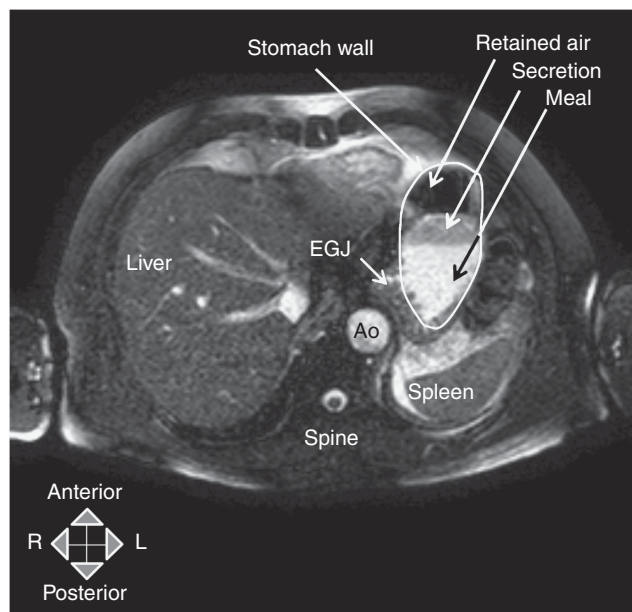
Magnetic resonance imaging (MRI) transverse section of abdomen at the T10 level of a healthy subject in the prone position 30 min after ingestion of a homogeneous 400 ml liquid nutrient test meal (300 kcal, 4.5 g fat/100 ml), stable in the acid environment of the stomach. The meal appears bright owing to paramagnetic contrast (Gadolinium-DOTA). A layer containing a much lower concentration of contrast is visible above the liquid meal. Validation studies have demonstrated that this is a layer of unbuffered gastric secretion that has not mixed with the meal in the proximal stomach (6,56). (Image courtesy of Mark Fox, Helen Parker, NIHR BRU, Nottingham, UK and Caroline Hoad, Carolyn Costigan, Sir Peter Mansfield MRI Centre, University of Nottingham, UK.). EGJ, esophagogastric junction.
